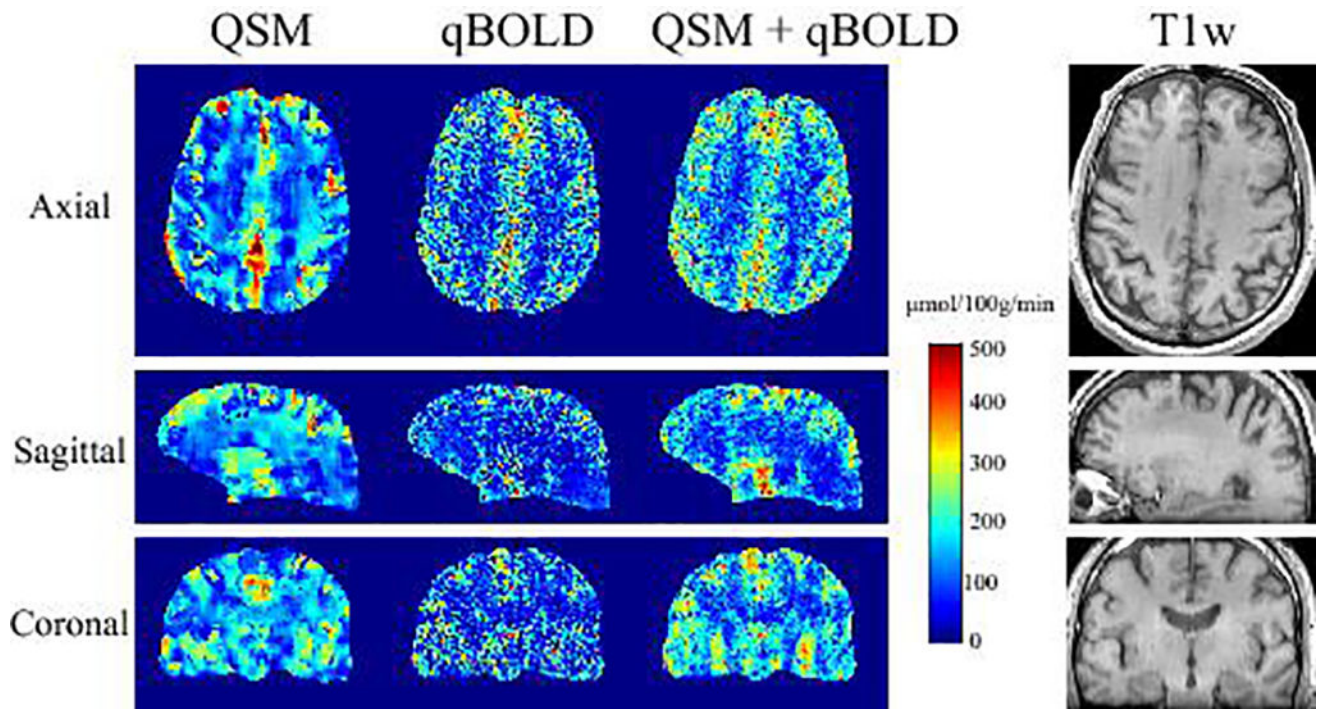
CMRO2 map in axial, sagittal, and coronal sections from a subject reconstructed using QSM, qBOLD, and QSM+qBOLD methods. The corresponding T1-weighted anatomical images are shown on the right. QSM+qBOLD shows higher GM/WM contrast than QSM or qBOLD.
